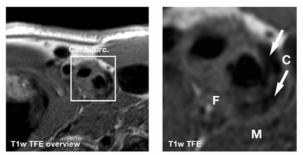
T1w TFE MR image of an atherosclerotic plaque in the internal carotid artery of an asymptomatic patient. This plaque was classified as a fibro-calcific because of the multiple small hypointense areas corresponding to calcifications (C, arrows). When compared to (a) there is no hyperintense signal corresponding to LRNC. Car. Bifurc: carotid bifurcation; F: fibrous tissue; M: muscle.
